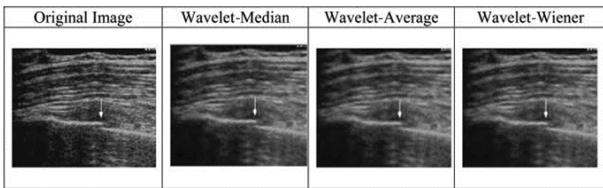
Rib fracture ultrasound image, sample 1.
